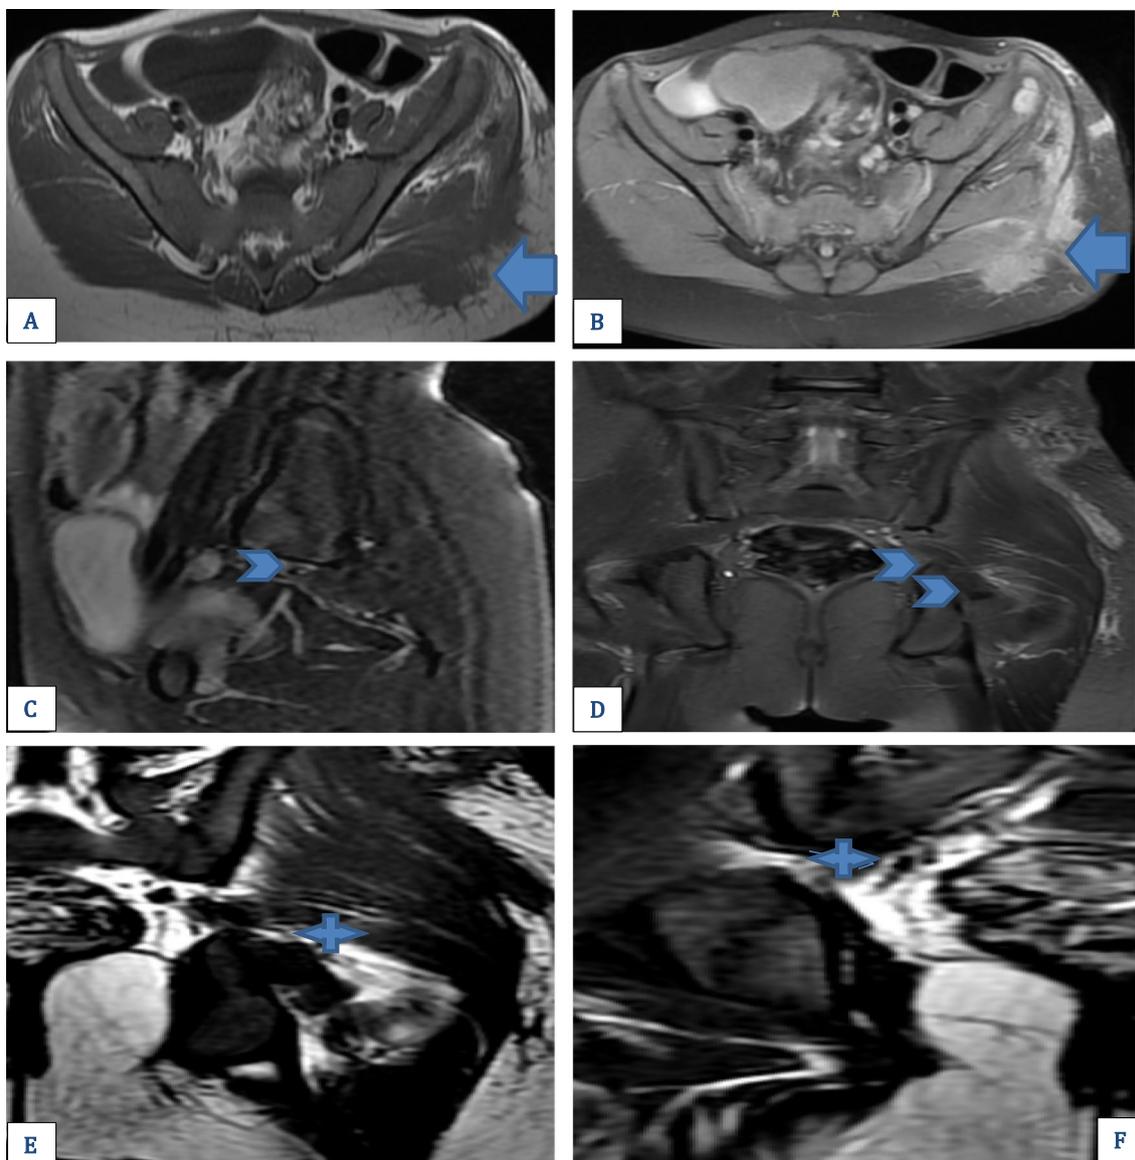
A 10-year-old boy patient, with a history of leukemia, previous left gluteal injection and followed by severe pain and gradual muscle weakness at the left thigh and foot. Electrophysiological studies revealed a +ve ipsilateral straight leg raising; MRI of the pelvis showed area of subcutaneous and left gluteal muscles collections associated with a focus of bone marrow leukemic infiltration in the left iliac crest (arrows in A and B). MRN shows a perineural edema related to the left sciatic nerve with mildly reduced thickness (open arrow in C and D), compared with the normal right-sided nerve (Arrow in E and F)
